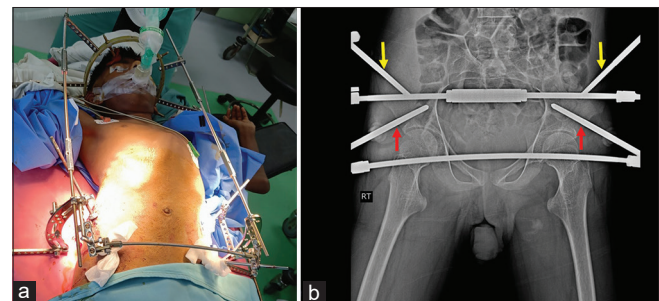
(a) Image of the patient just after the placement of halo-pelvic assembly. (b) Radiograph showing exact position of half pins in pelvic assembly; supra-acetabular half pins (red arrows) half pins in ilium (yellow arrows).
